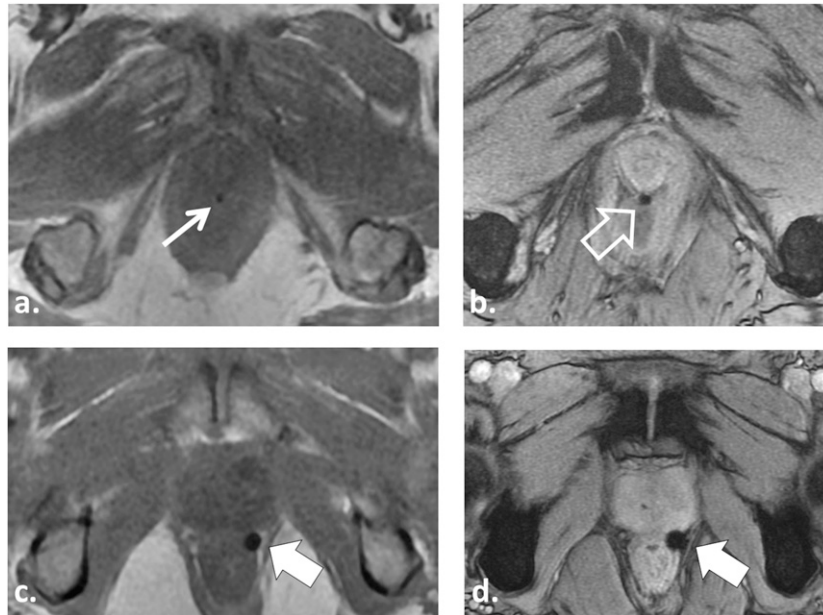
57 year old undergoing radiotherapy (RT) planning MRI for intensity-modulated radiotherapy after insertion of three gold seed fiducial markers. Axial T_1 weighted (T1W) in-phase (IP) gradient recalled echo (GRE) image (a) barely demonstrates the gold fiducial marker (white arrow). Axial multiecho gradient recalled echo (ME-GRE) image (b) provides better depiction of the gold fiducial marker (open white arrow). A 52-year-old patient undergoing RT planning MRI for stereotactic body radiotherapy after insertion of three platinum fiducial markers demonstrates improved visualization of platinum compared with gold fiducials owing to the greater magnetic susceptibility of platinum. The platinum fiducial (solid white arrows) is easily identified on both T1W IP GRE (c) and ME-GRE (d).
